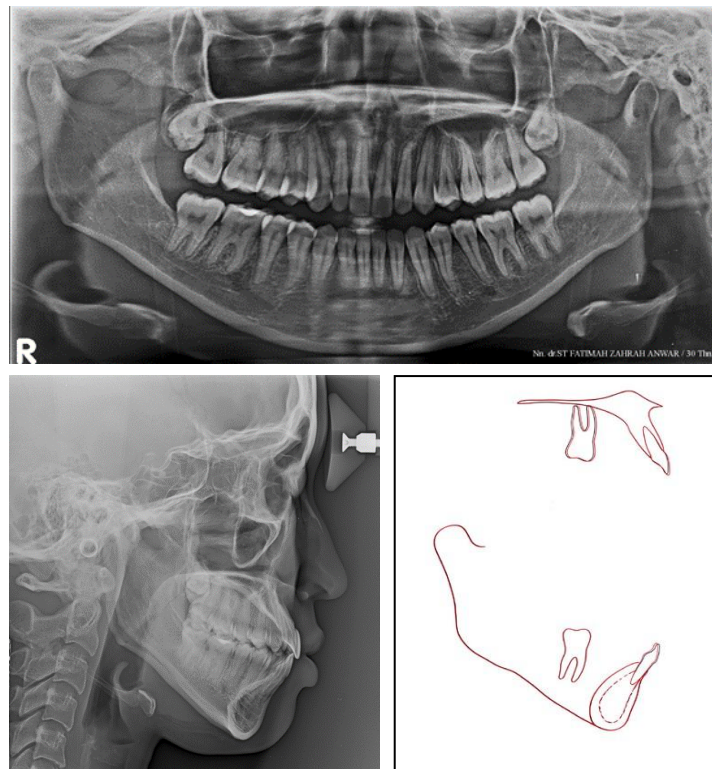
Post-treatment panoramic and cephalometric radiograph
